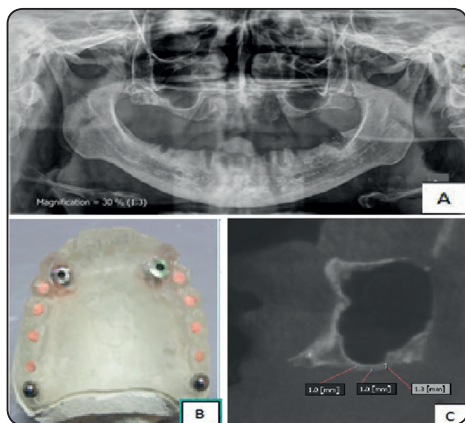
(A) Pre-operative panoramic radiograph showing severe pneumatization of maxillary sinus, (b) transparent acrylic radiographic/ first surgical stent (c) coronal cut showing remaining alveolar crest 1.0 mm
